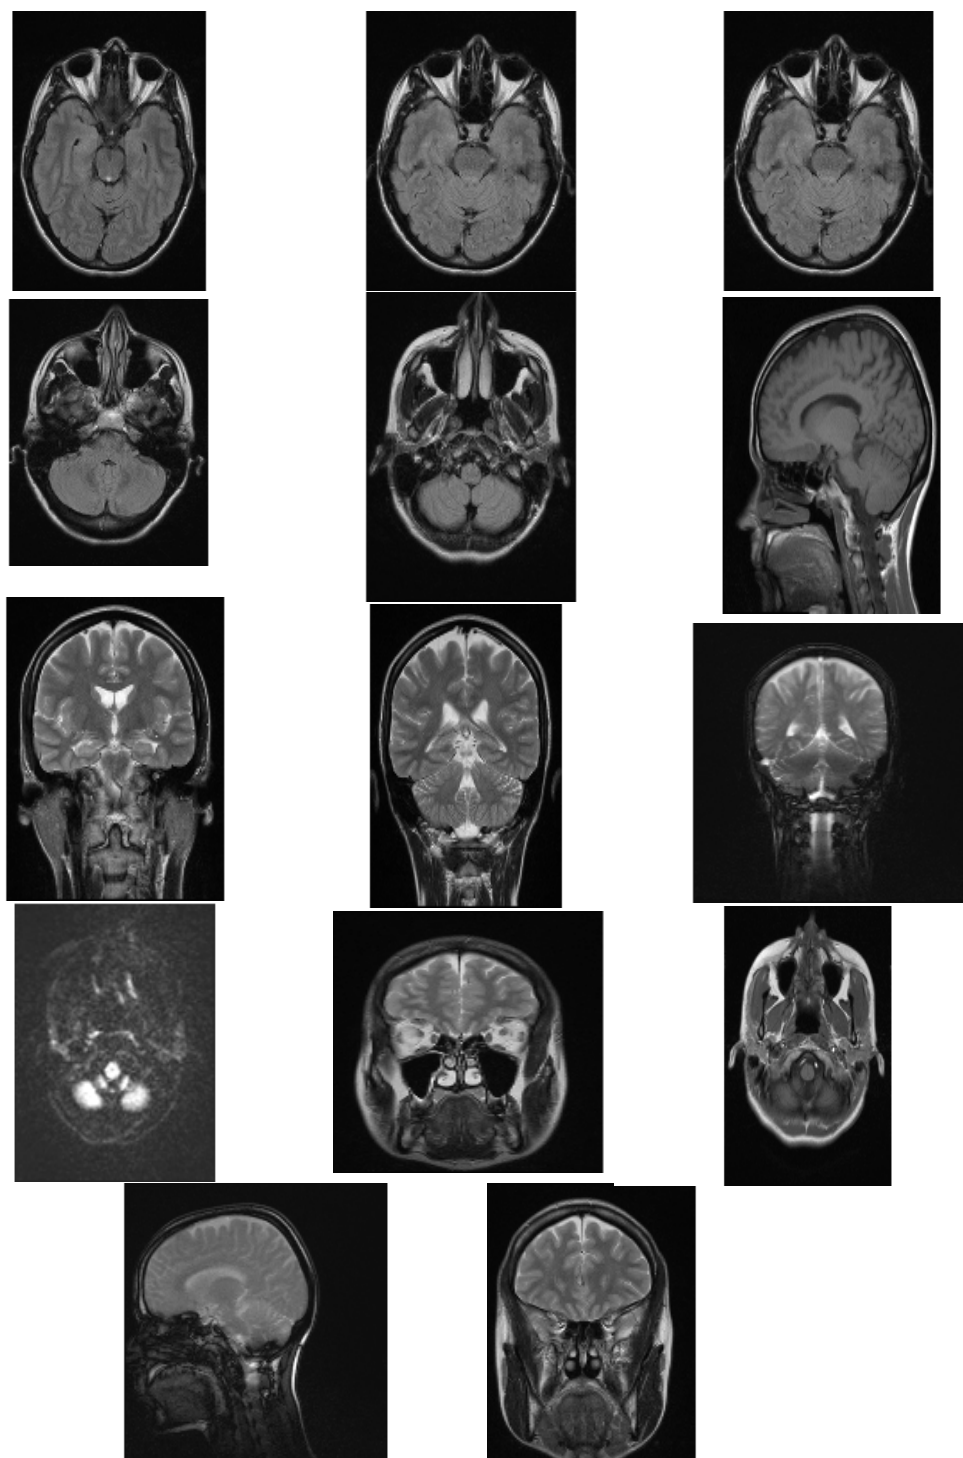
MRI neuroimaging in axial, sagittal and coronary plane
